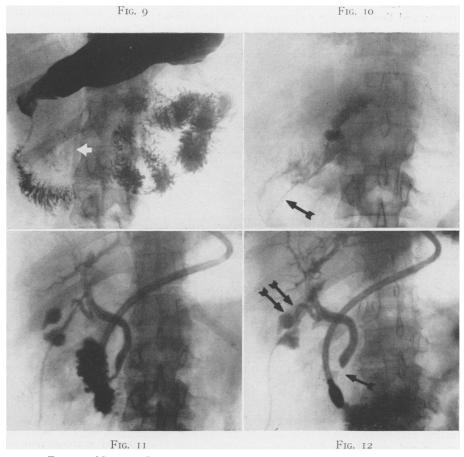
(Case 4) Preoperative roentgen ray studies showed calcification of the head of the pancreas (arrow) with marked narrowing and distortion of the duodenum.
